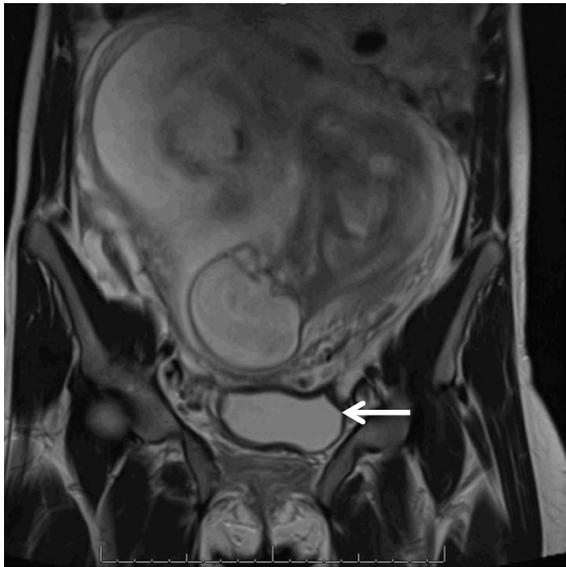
Coronal view from MRI of pelvis without contrast at 24 6/7 weeks from Case 2 demonstrating a normal uterus and thickened bladder edge (white arrow).
